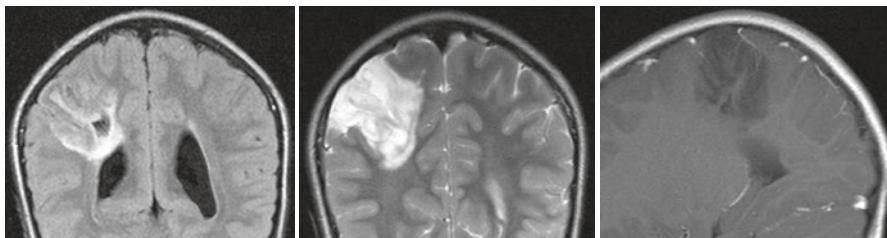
MRI coronal FLAIR (left), coronal T2 (middle), and sagittal T1 post gadolinium (right) of a patient with epilepsy since age 5 and found to have a DNET. (Images courtesy of Dr. Anton Hasso)
